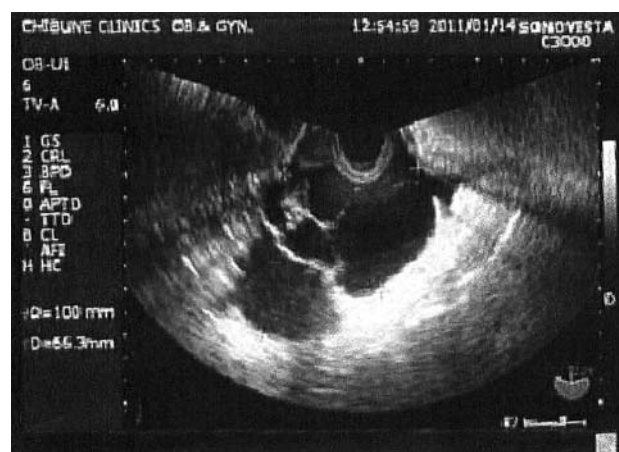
Case 2: transvaginal ultrasound image revealing enlargement of a multilocular cyst up to 100×66.3 mm.
